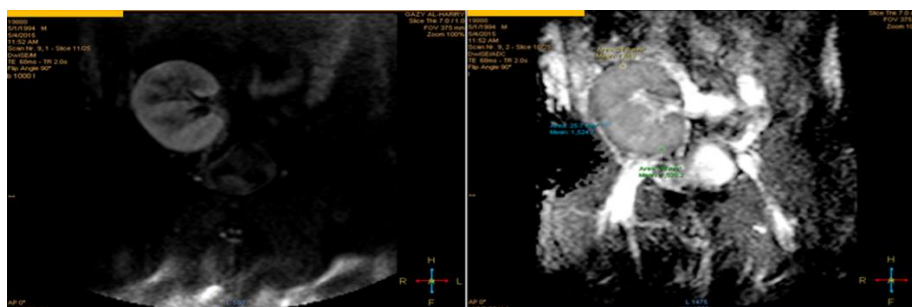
Coronal DWI and ADC for patient with CNI nephrotoxicity of renal allograft, the ADC map showing homogeneous low mean ADC values of renal parenchyma.
